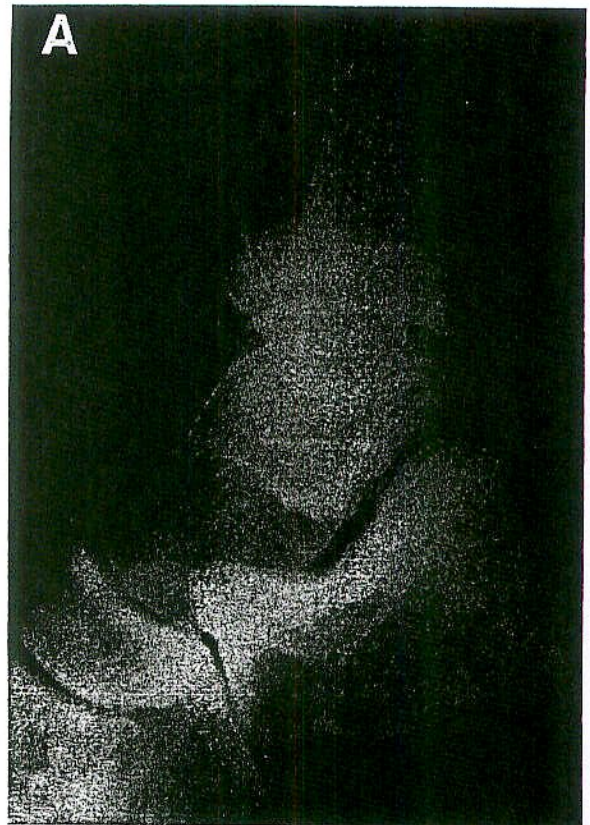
A, Lateral view of the left ankle: normal radiographic examination. B, Anteroposterior view of the left ankle: normal radiographic examination.
